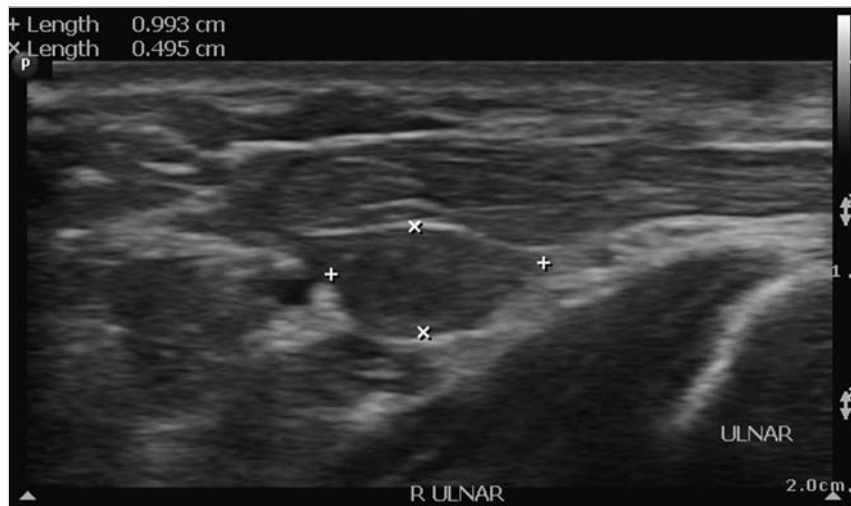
Ultrasound evaluation of the free muscle graft.
